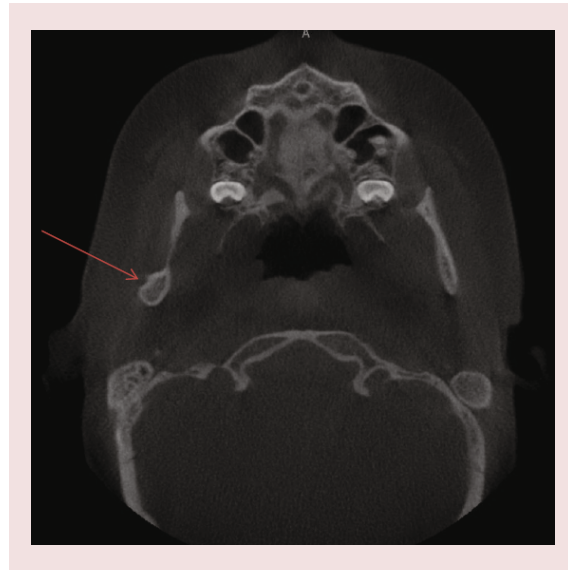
Computed tomography appearance of chronic temporomandibular joint arthritis in a 12-year-old female with polyarticular juvenile idiopathic arthritis. Her right condyle has undergone erosive changes (arrow.)
